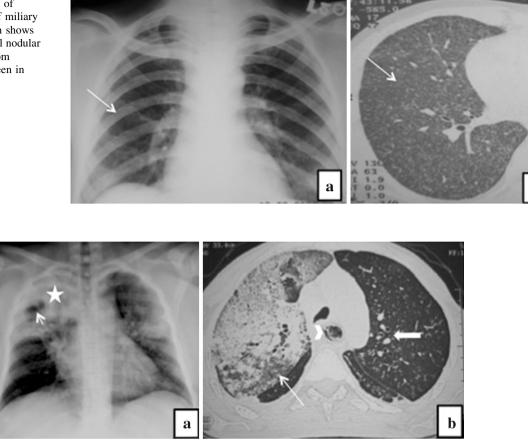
Klebsiella Pneumonia* in two different patients. a Chest radiograph shows the presence of lobar consolidation (*asterisk*) with break down and cavitation (*small white arrow*) in right upper lobe. b Chest CT shows the presence of lobar consolidation with bulging fissures (*long white arrow*). Note the stent in esophagus (*white arrow head*) and centrilobular nodules in left upper lobe (*white block arrow*)
